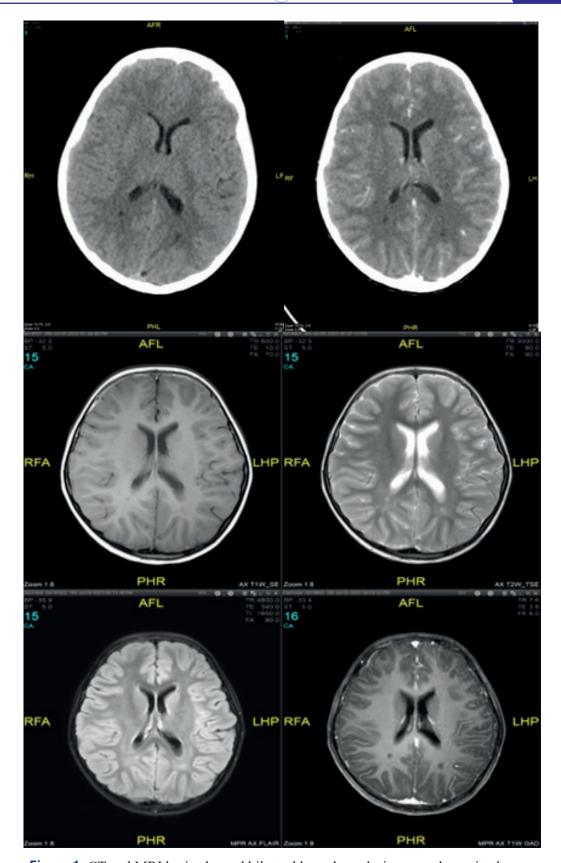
CT and MRI brain showed bilateral hypodense lesion over the parietal area.
